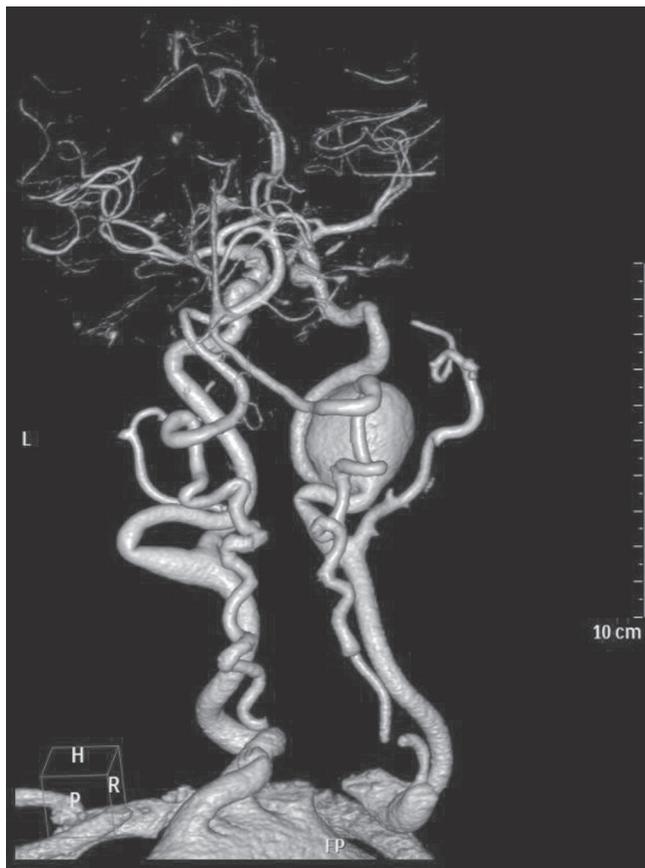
3D CTA of a saccular aneurysm of the ICA. 3D: 3-dimensional, CTA: computerized tomographic angiography, ICA: internal carotid artery.
